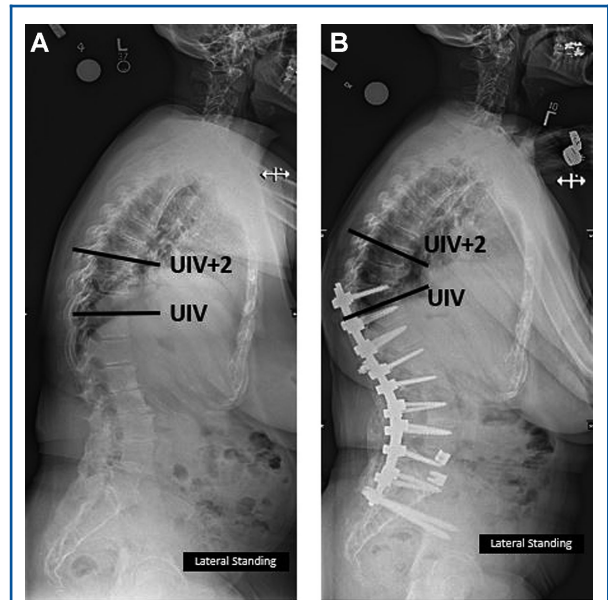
A, B, Preoperative and postoperative standing long-cassette lateral radiographs of a 73-yr-old female with spinal deformity show the proximal junctional angle (PJA) measuring 16.2° and 29.3° , respectively. PJA was the sagittal Cobb angle measured from the caudal endplate of the uppermost instrumented vertebra (UIV) to the cephalad endplate of UIV+2 (2 supra-adjacent levels above the UIV). For this study, abnormal proximal junctional kyphosis (PJK) was defined as a PJA (1) greater than or equal to 10° and (2) at least 10° greater than the corresponding preoperative measurement. The presence of both criteria was necessary to be considered abnormal. B, This patient developed postoperative PJK.
